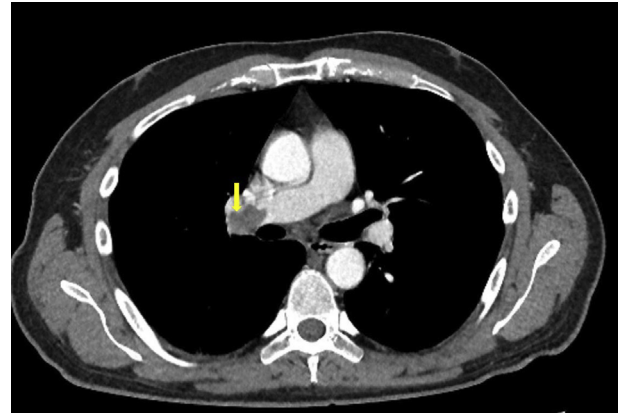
An axial cut of a computed tomographic scan of the chest showing large thrombus in the distal right main pulmonary artery (arrow).
